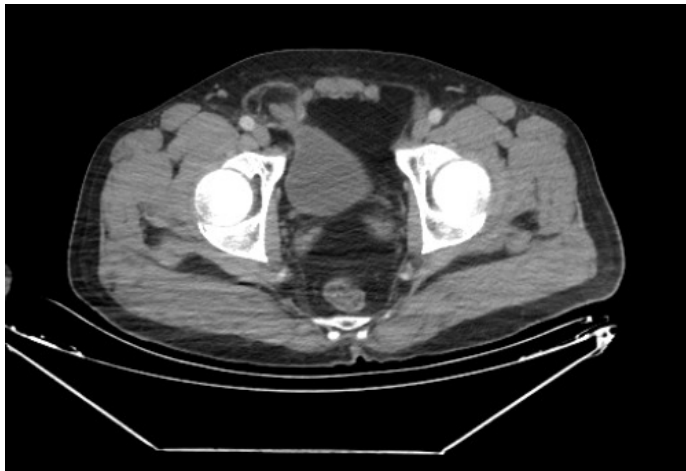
Right inguinal bladder herniation on axial computed tomography images
